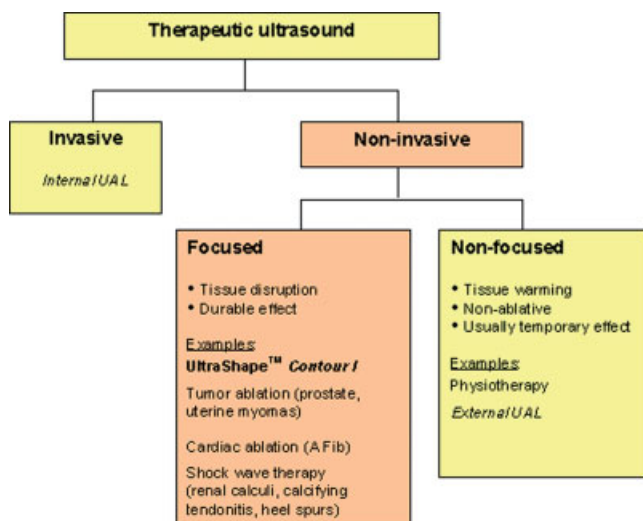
Therapeutic ultrasound approaches and characteristics. UAL-ultrasound assisted liposuction; A Fib—atrial fibrillation.
